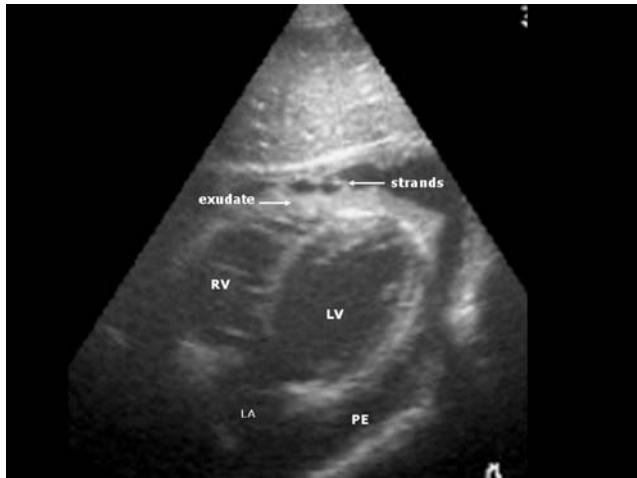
Echocardiography showing a large pericardial effusion with exudative debris and fibrin strands. *RV* right ventricle, *LV* left ventricle, *LA* left atrium, *PE* pericardial effusion
